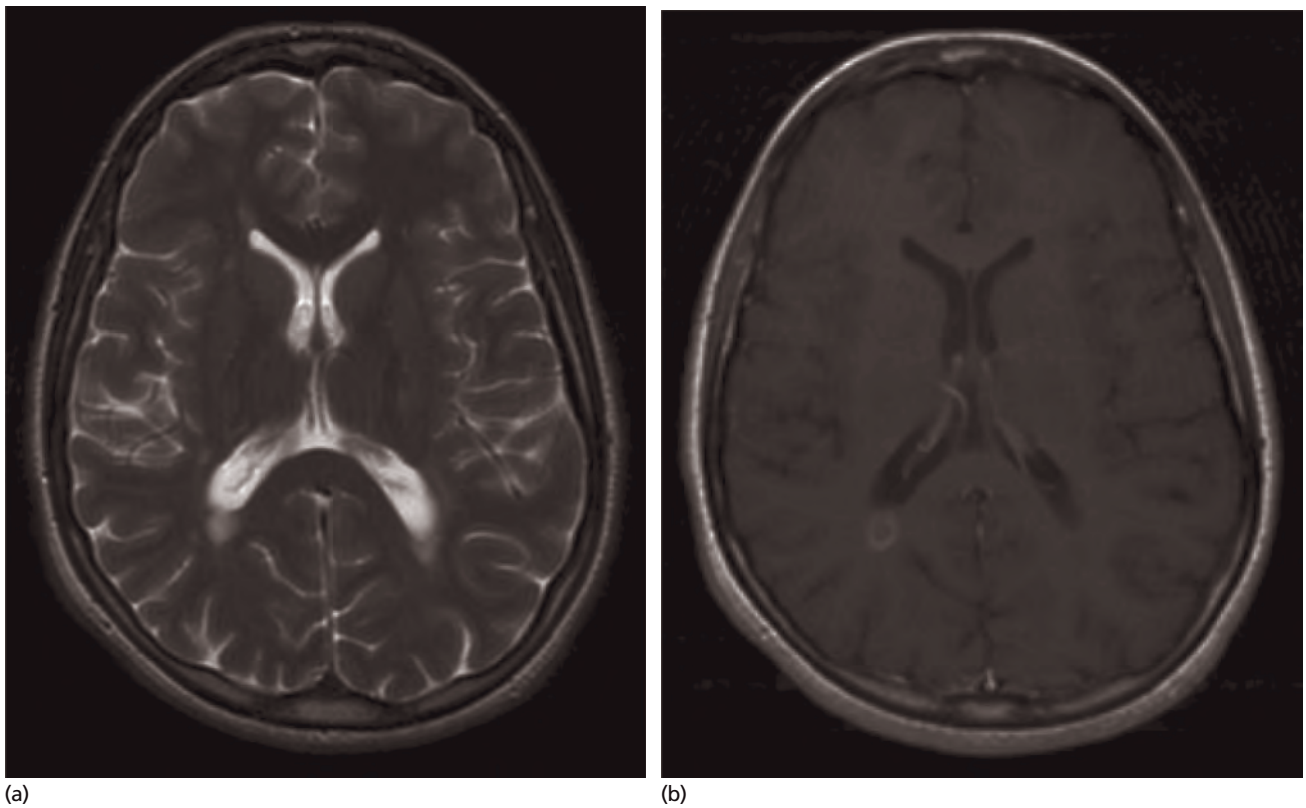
Typical Lesions in multiple sclerosis: (a) an acute periventricular lesion (MRI T2W); (b) associated gadolinium enhancement (MRI T1W axial).
